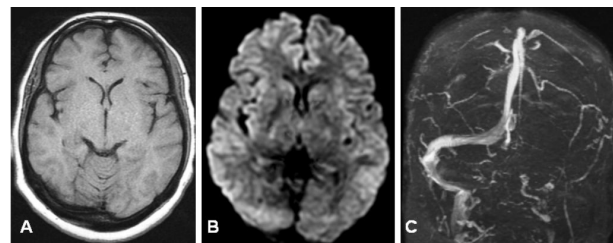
Normal T1 (a) and diffusion weighed (B) MRI with evidence of absent left transverse sinus (C) on MRV.
